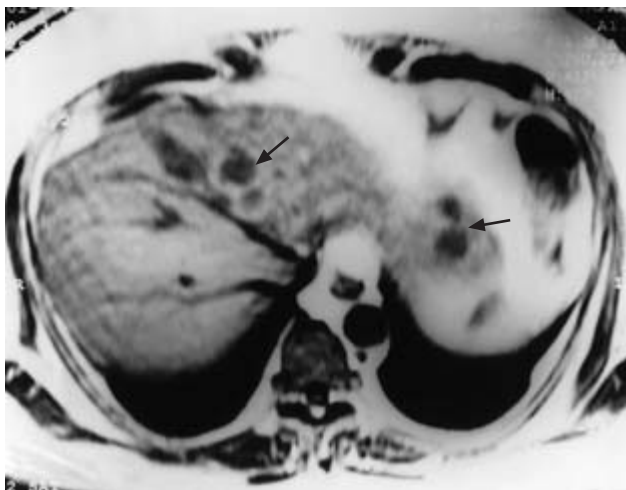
MRI shows multiple hepatic metastases in both lobes but especially along the hepatic vein (arrows).
